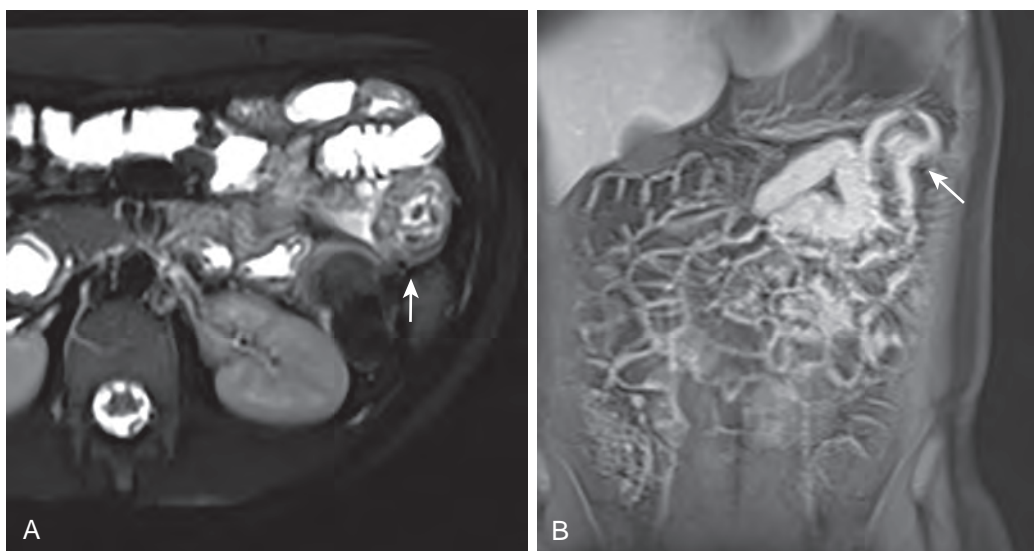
Henoch-Schönlein purpura: MR enterography. A. Axial T2-weighted half-Fourier acquisition single-shot turbo spin-echo (HASTE) fat-saturated image shows focal, circumferential wall thickening of a loop of jejunum in the left upper quadrant (arrow). B. Coronal T1-weighted fat-saturated three-dimensional volume-interpolated breath-hold examination (VIBE) delayed image after intravenous administration of gadolinium demonstrates abnormal wall enhancement of the same loop of bowel (arrow).
